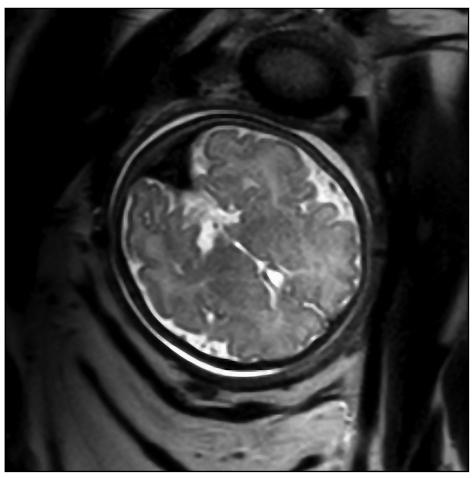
The regression of tDSM documented on fetal axial T2W MRI at 35 weeks 3 days of gestation
